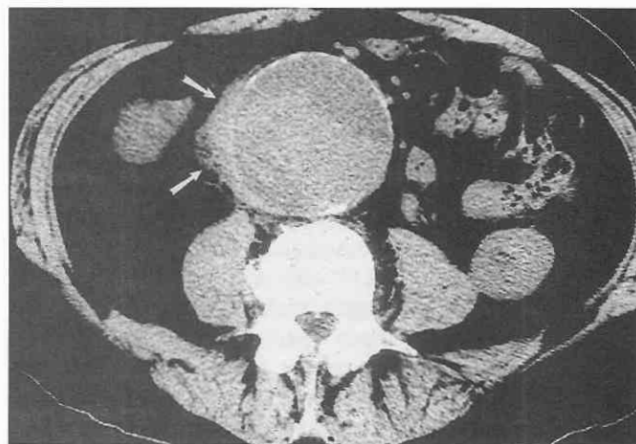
Perianeurysmal fibrosis mimicking aortic rupture. Poorly defined soft tissue attenuation material surrounds the right lateral aspect of the abdominal aorta (arrows) on an unenhanced CT scan. The patient had presented with acute severe back pain. The periaortic soft tissue was suspected to represent a small contained aneurysm rupture. At emergency surgery, only retroperitoneal fibrosis was found.
